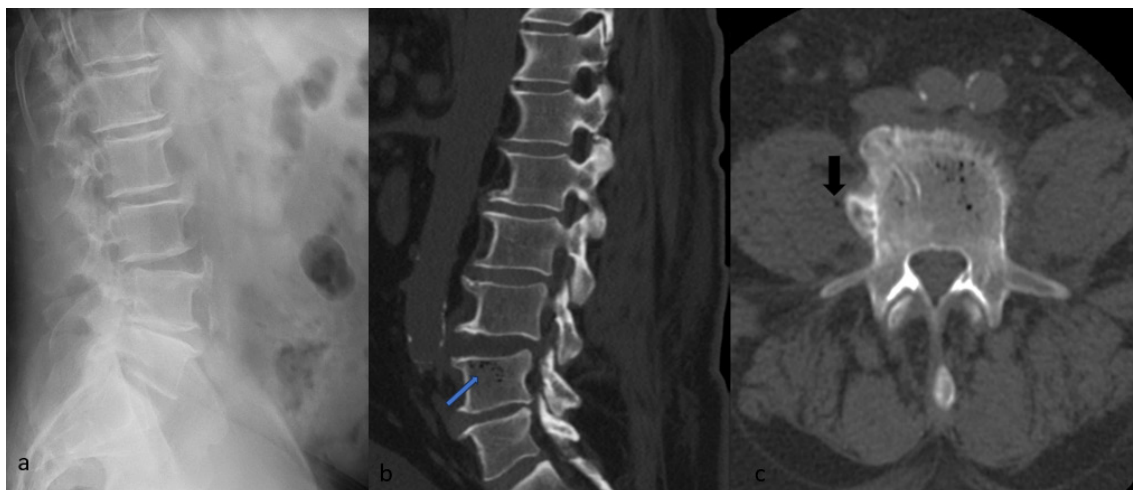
Lumbar x-ray was unremarkable (a). CT scan of the lumbar spine showed multiple bubbles of air within the L4 vertebral body (blue arrow) with an extension of gas into the right psoas muscle (black arrow) (Fig1b,c).
